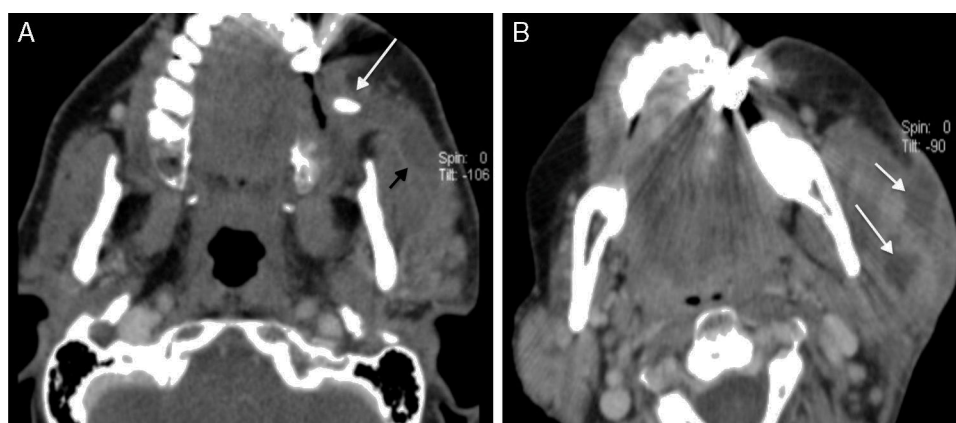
Salivary facial swelling. (A) Computed tomography (CT), axial section with IV contrast. Left *Parotitis* with sialoectasia (black arrow) secondary to lithiasis (white arrow). (B) CT, axial section with IV contrast of another patient with parotitis and formation of secondary *intraparotid abscesses* (white arrows).
